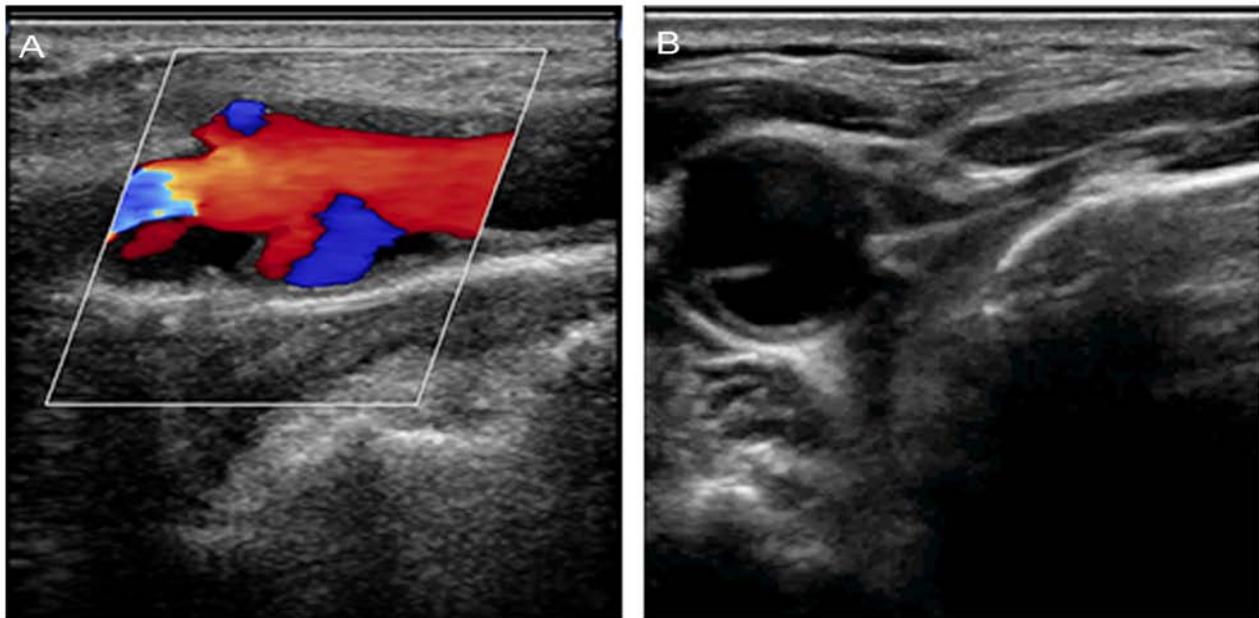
Color duplex scan of the carotid vessels. (A) Two cysts, in which red and blue flow signals were detected by carotid ultrasonography, communicated with the right CCA and the origin of the right ICA separately. (B) Right CCA and the origin of the right ICA were compressed by the hyoid bone repeatedly when swallowing and speaking. Video is available. CCA, common carotid artery; ICA, internal carotid artery.
